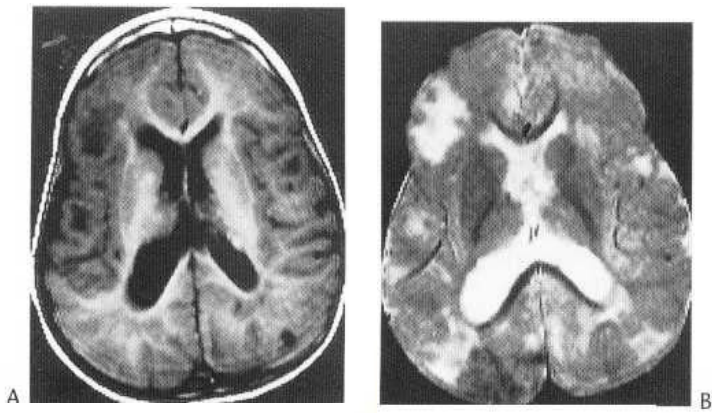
MRI studies of a patient with tuberous sclerosis shows cortical tubers as: (A) low signal (T₁-weighted); (B) high signal (T₂-weighted). Calcification is not specifically identified but appears as low signal in the intraventricular tubers.
